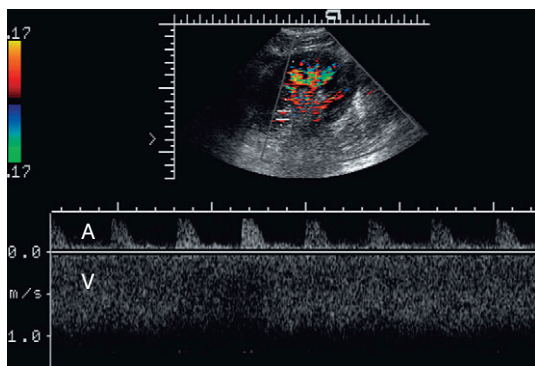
Spectral Doppler tracing of the renal vascular pedicle incorporating both the arterial (A) and venous (V) waveform. Note the high velocity in the vein approximating 1 m s^{-1} . Note the corresponding high resistance arterial waveform. A renal vein stenosis due to scarring was identified at surgery.
